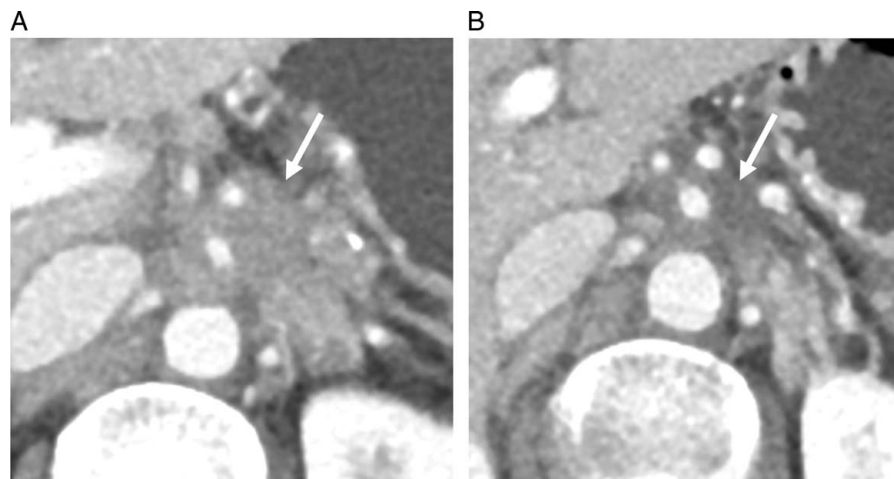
A 76-year-old woman with locally advanced pancreatic ductal carcinoma who underwent neoadjuvant chemotherapy. (A) Baseline axial intravenous (i.v.) contrast-enhanced computed tomography (CT) image in the portal venous phase showed a locally advanced tumor (arrow) with encasement of the celiac artery, common hepatic artery, and splenic artery. (B) Restaging CT after neoadjuvant therapy showed decreased tumor size and replacement of solid tumor contact with an ill-defined perivascular halo. The patient underwent distal pancreatectomy with a complete response on pathology examination.
